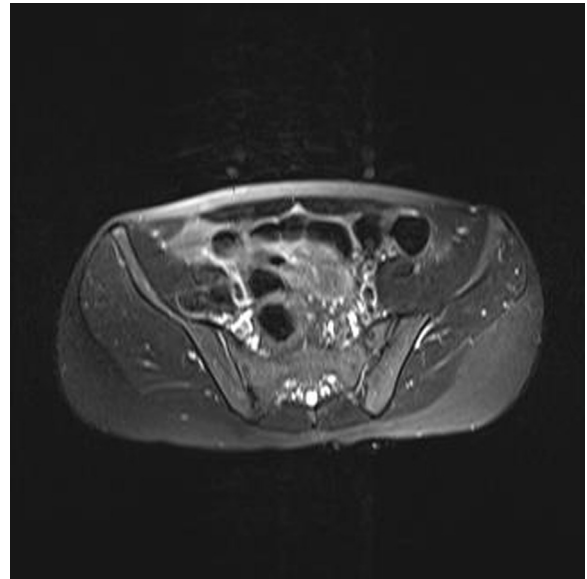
Magnetic resonance imaging in the patient. The image shows hyperintensity, demonstrated by the linear white highlight, of the right sacroiliac joint, when compared with the left. This finding was suggestive of inflammation and fluid, which ultimately aided in diagnosis of infectious sacroiliitis.
